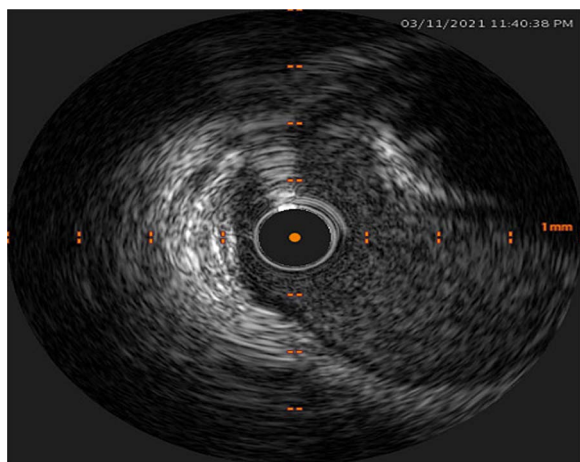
Repeat intravascular ultrasound (IVUS). Eccentric fatty/fibrotic plaque in proximal left anterior descending (LAD) coronary artery with mild calcification.
